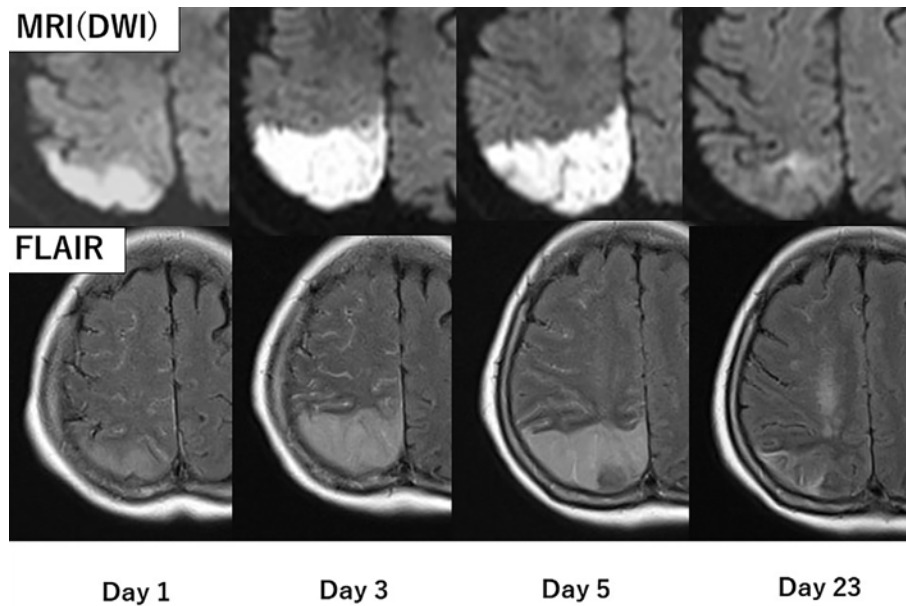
The comparison of FLAIR and DWI on admission and at 3, 5, and 23 days after admission. These comparisons show increased and expanded ipsilateral ivy sign paralleling expansion of the cerebral infarction. Five days after admission, progression of cerebral infarction had stopped on DWI, and the ivy sign was also diminished 23 days after admission. All immediate MRI studies were performed on a 1.5-T scanner (Siemens Healthcare, Erlangen, Germany) to examine patients with suspected stroke, including DWI, FLAIR, and MRA. DWI was performed with a standard protocol using the following parameters: field of view (FOV), 220 mm; spatial resolution, $1.7 \times 1.7 \times 5.5$ mm; and b-values of 0 and $1,000 \text{ s/mm}^2$. FLAIR was performed in the axial plane (FOV, 220 mm) with a common spatial resolution of $0.9 \times 0.9 \times 5.5$ mm.
